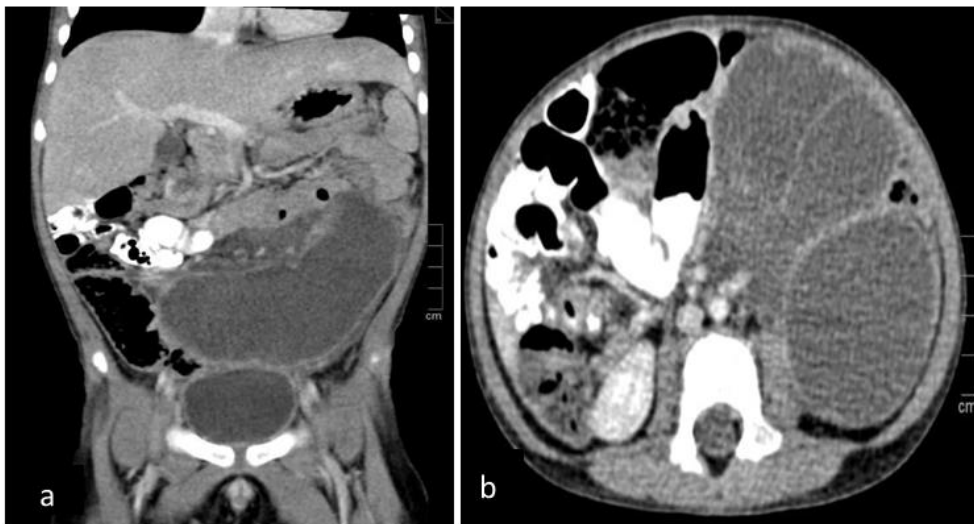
(a-b): Contrast enhanced computed tomography (CT) of the abdomen in coronal and axial views showing a well-defined multifolliculated intra peritoneal cystic lesion measuring 8cm x 7cm x 13cm occupying left lower abdomen
